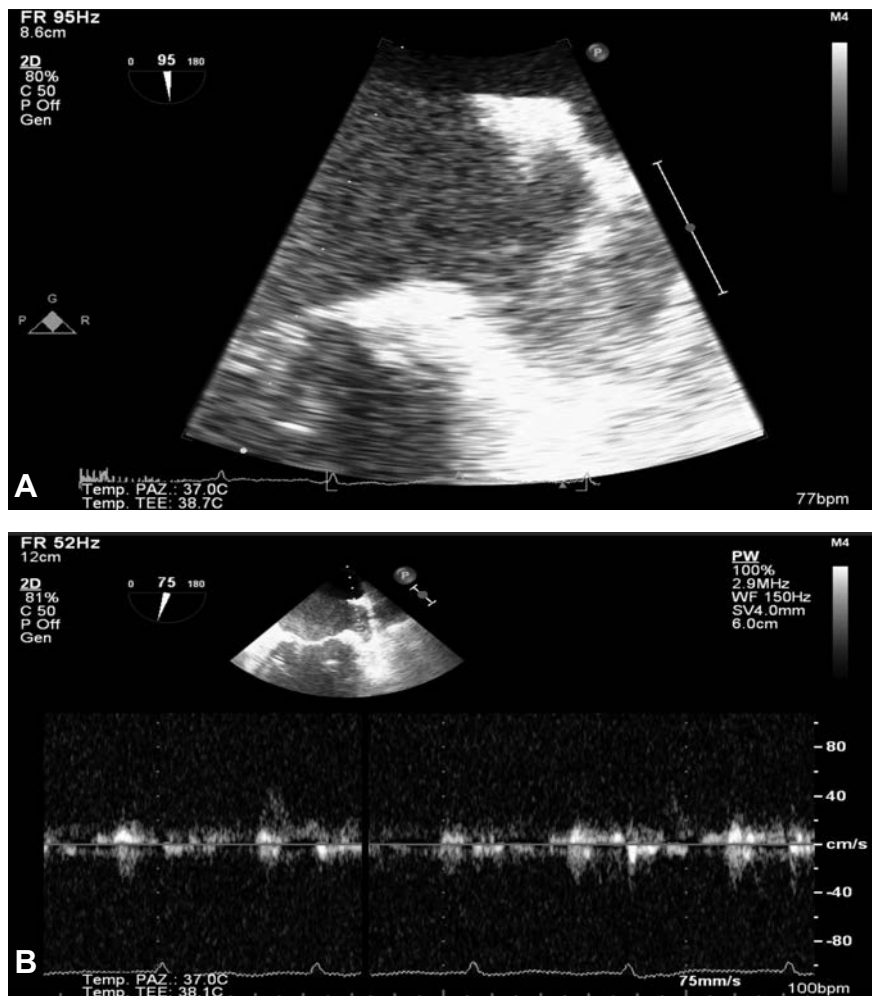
A) Trans-esophageal echocardiogram (TEE) showing a thrombus in the left atrial appendage and low auricular flow; B) TEE showing a low auricular flow.
